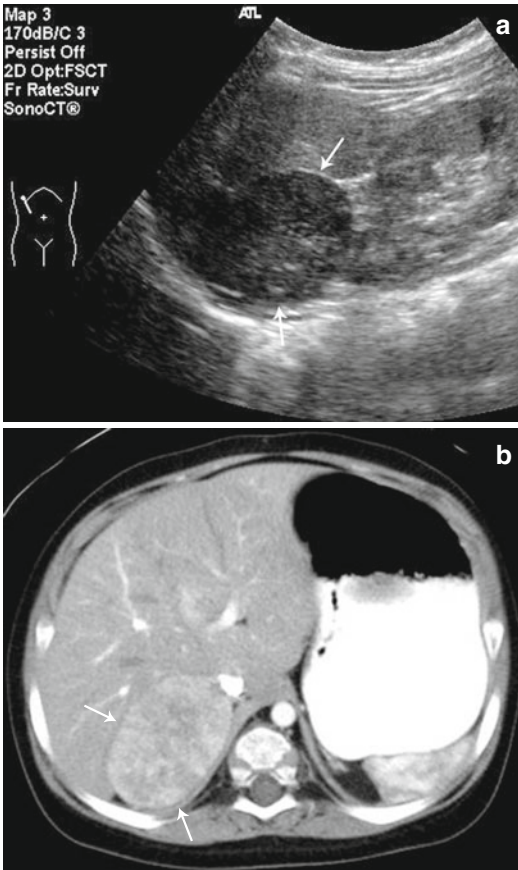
Adrenocortical neoplasm. US (a) and CT (b) images through the upper abdomen reveal a solid soft tissue mass (arrows) found to be an adrenocortical neoplasm
